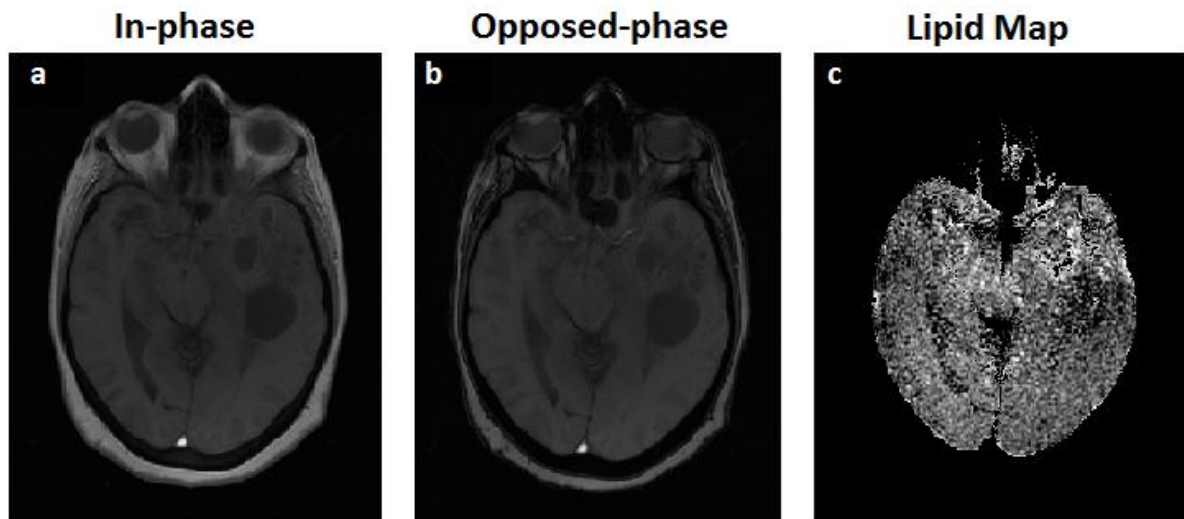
Axial MRI images showing a) in-phase image, b) opposed-phase image, and c) the skull-stripped lipid map constructed from the subtraction of in- and opposed-phase MRI images.
